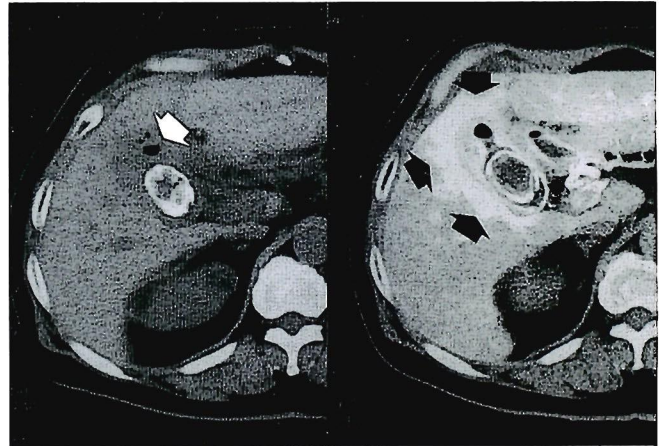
A CT scan showing the presence of gas (white arrow) in the gallbladder (Left, Case 4), and an angio-CT scan revealing a hypervascular mass (arrow) in the liver bed with a clear border in the gallbladder wall (Left, Case 4).
